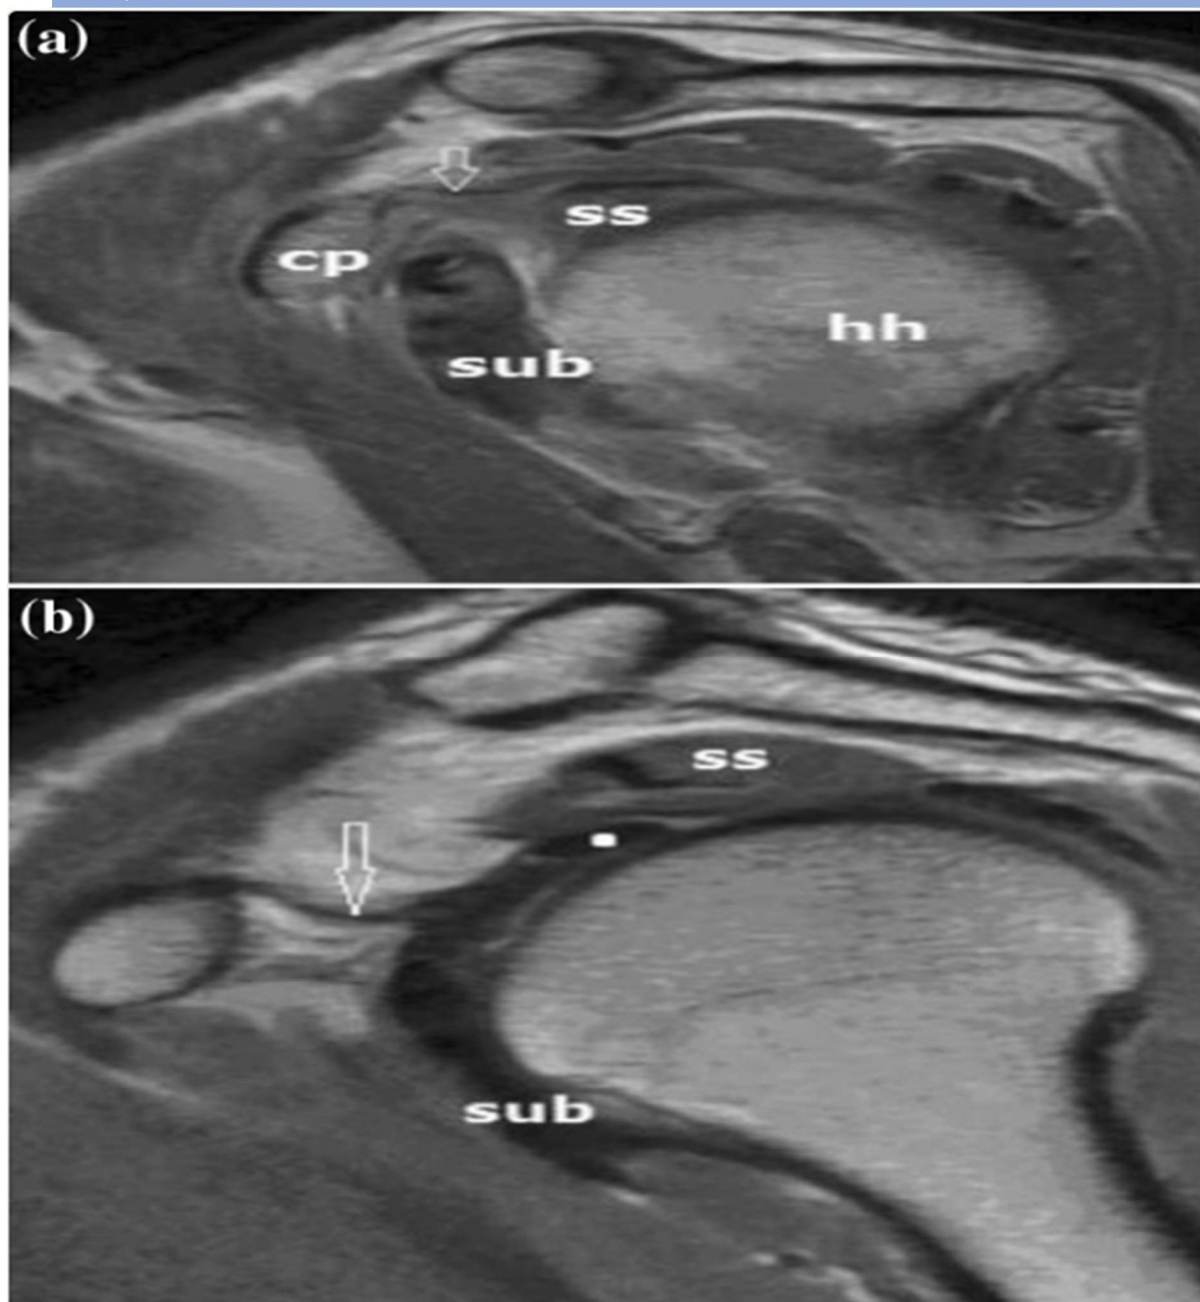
MRI Visualization of Shoulder Pathology in Adhesive Capsulitis (a Sagittal MR image in a subject with adhesive capsulitis shows poorly defined soft tissue intensity encasing the CHL (arrow). b Normal rotator interval for comparison. Note the thin dark band of the CHL (white arrow) coming to sit above the bicep's tendon (white dot), beneath the supraspinatus (ss). Subscapularis (sub) is shown.)
